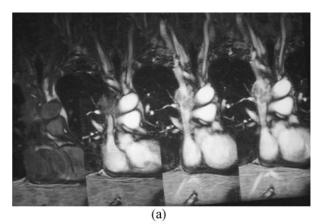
(a) Superior venacava tumor in cardiac-gated MRI before (left image) and after injection of Gadolinium, at different times of injection (following images from left to right) (courtesy of D. Buthiau on a Signa 1,5 T from G.E.M.S); (b) Hepatocarcinoma before and after injection of Gadolinium, in perfusion MRI, defining consistency, vascularity, extension, infiltration and vascular atypies and spread.
